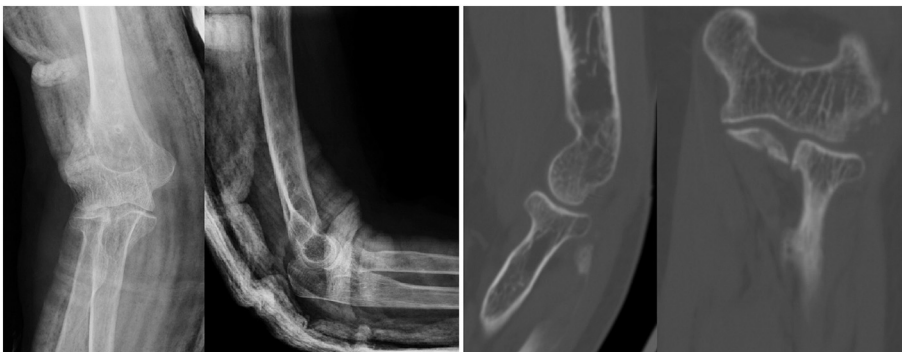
X-Ray and CT-scan performed after closed reduction and immobilization, showing a correct reduction.
